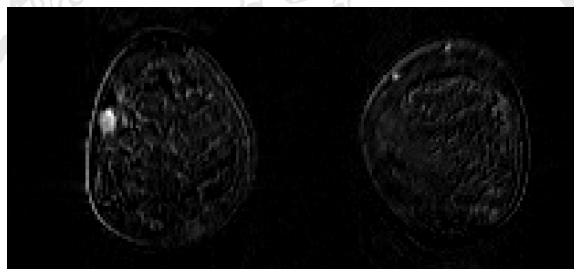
A subtractive DCE-MRI image
